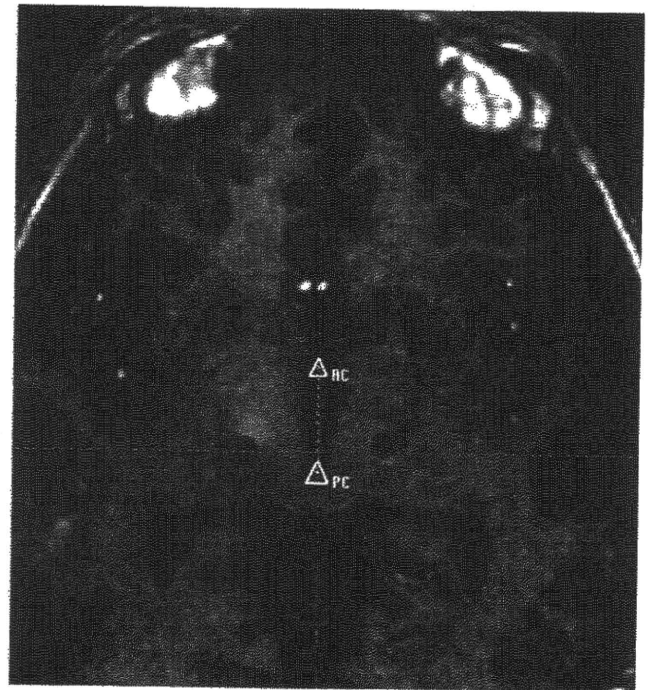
Location of bilateral DBS electrodes on magnetic resonance (MR) imaging. Postoperative T₁-weighted axial MR imaging of the brain revealed the lead locations at the level of the AC-PC commissural plane. The leads are visualized as dark circular spots in the brain parenchyma.
